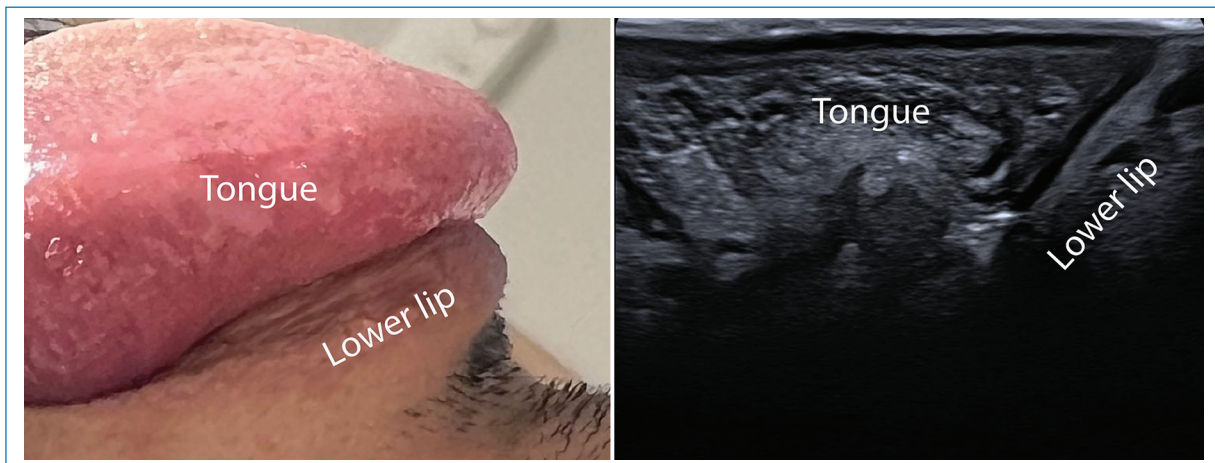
Comparative images from a lateral view of the tongue by photography and in a cross section by ultrasound with the “hockey stick” type transducer.
